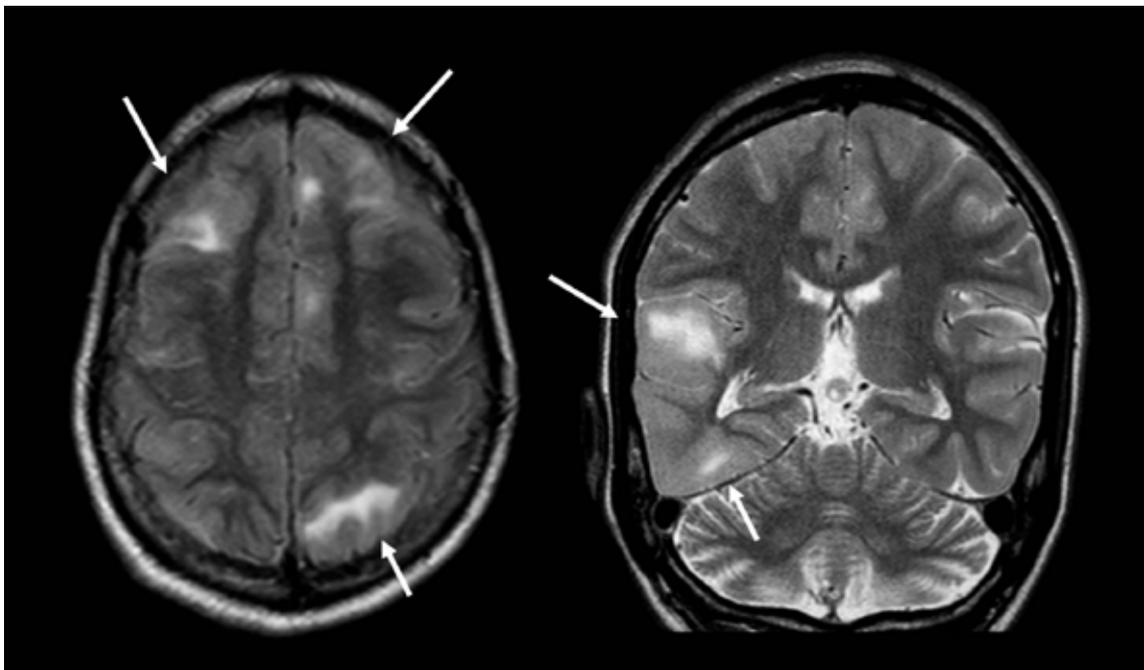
FLAIR axial and coronal T2-W MRI sequences showing cortical tubers (arrows).
